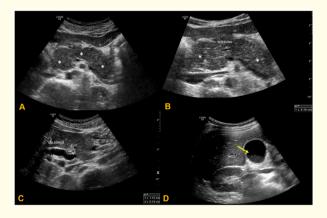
Abdominal ultrasound. A. Homogeneous enlargment of the pancreas with associated slightly decreased echogenicity and some echogenic punctate and linear images (asterisks). B. No dilatation of the Wirsung's duct. C. Dilatation of the main bile duct with abrupt decrease in size at the intrapancreatic segment. D. Gallbladder slightly distended with echogenic material suggestive of biliary sludge (yellow arrow).
